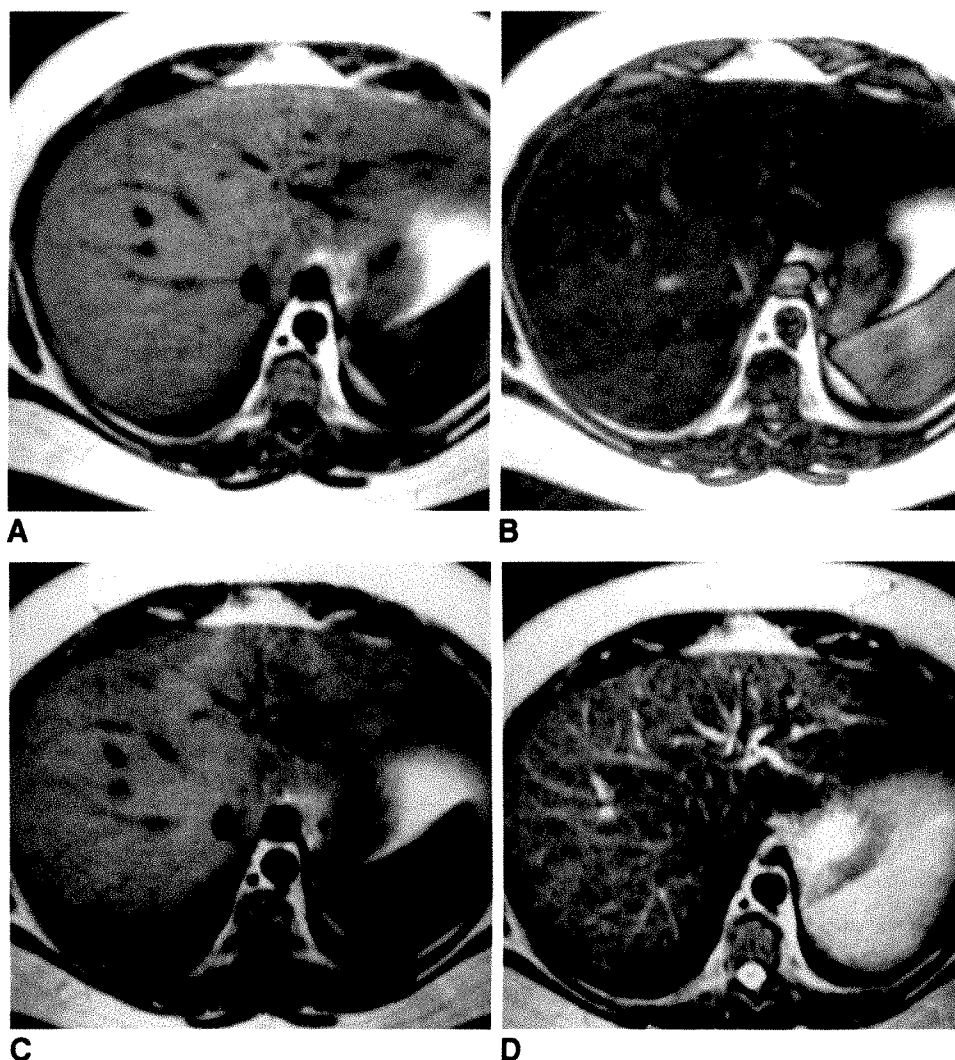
A–D, MR images of patient with MR-calculated fat percentage of 42% and biopsy grade 3. A–C are 0°, 180°, and 360° out-of-phase images, respectively. D is T2-weighted image. Note marked decrease in signal of liver on out-of-phase image B.
